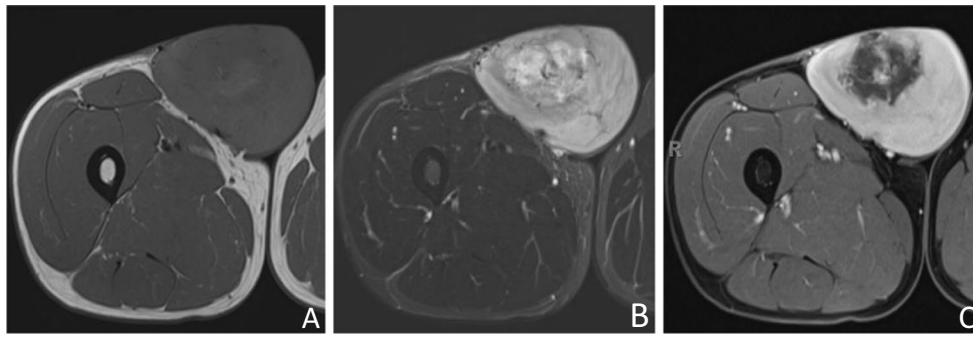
Axial (a) T1-w, (b) STIR, and (c) fat-suppressed T1-w contrast-enhanced MRI of the right thigh
